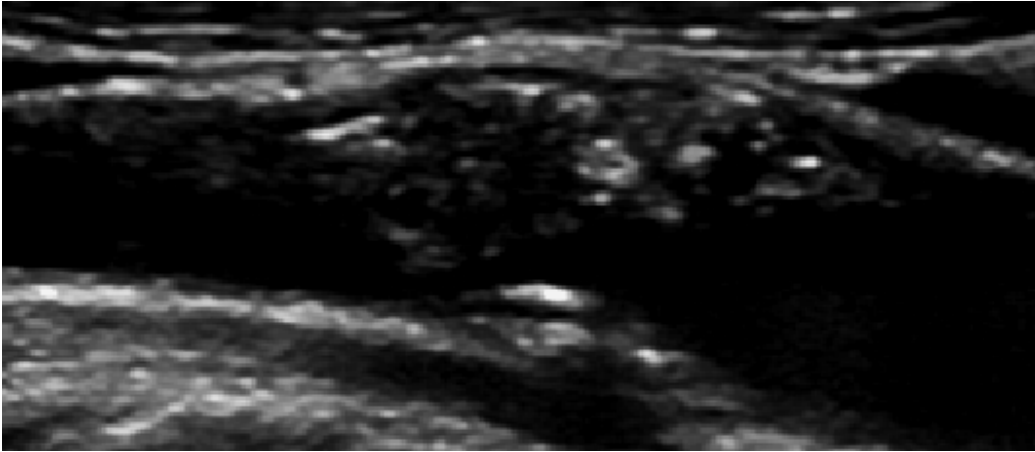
Longitudinal color ultrasonic image of the above echolucent, heterogeneous plaque
